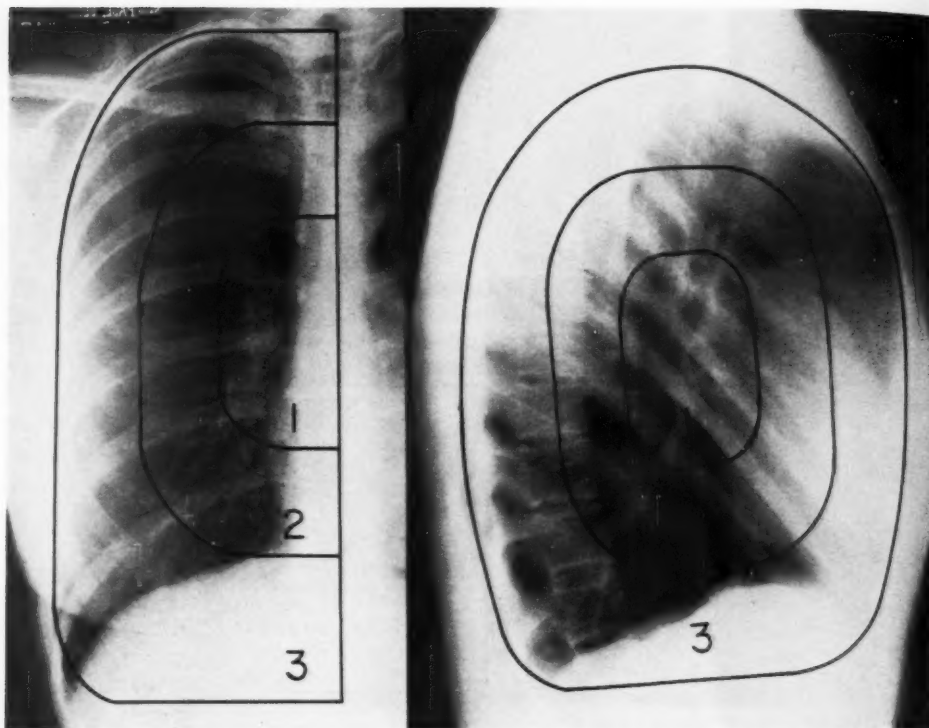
Postero-anterior and lateral roentgenograms of the chest showing zonal divisions of the lung used in this study: 1. Hilar zone. 2. Mid zone. 3. Peripheral zone.
